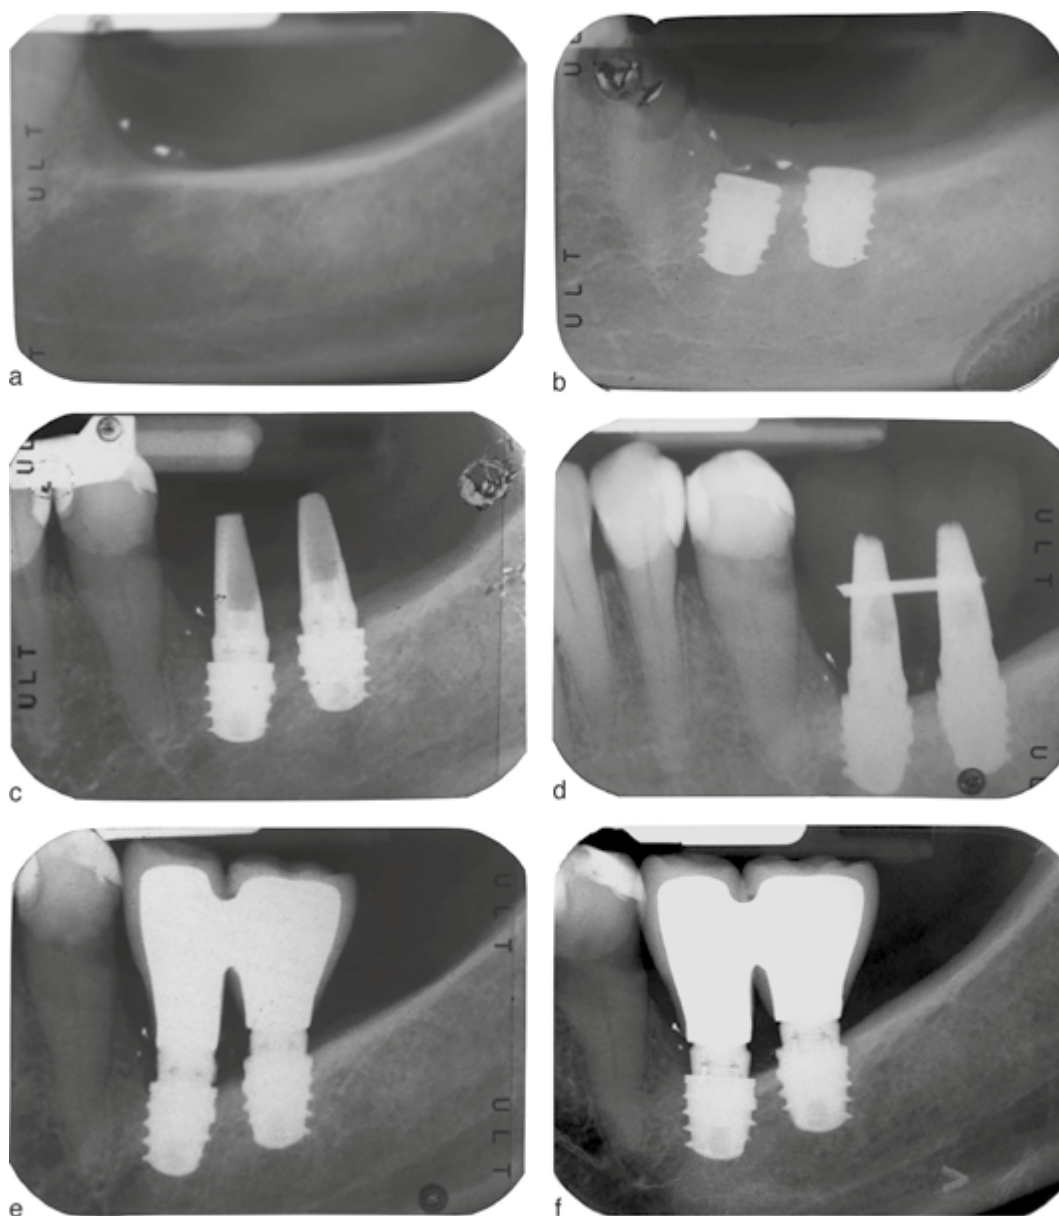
CONTINUED. (a) Preoperative radiograph. (b) Postoperative periapical radiograph. (c) Radiographic examination after abutments connection. (d) Radiographic examination after provisional prosthesis. (e) Periapical radiograph taken at delivery of the definitive fixed dental prosthesis. (f) Radiograph after 3 years of functional load.
